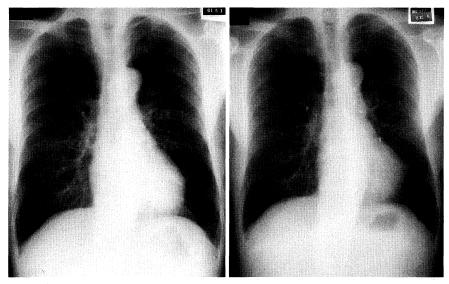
Preoperative and postoperative (50 months after second carinal resection without lung resection) chest x-ray films of a 62-year-old man.
